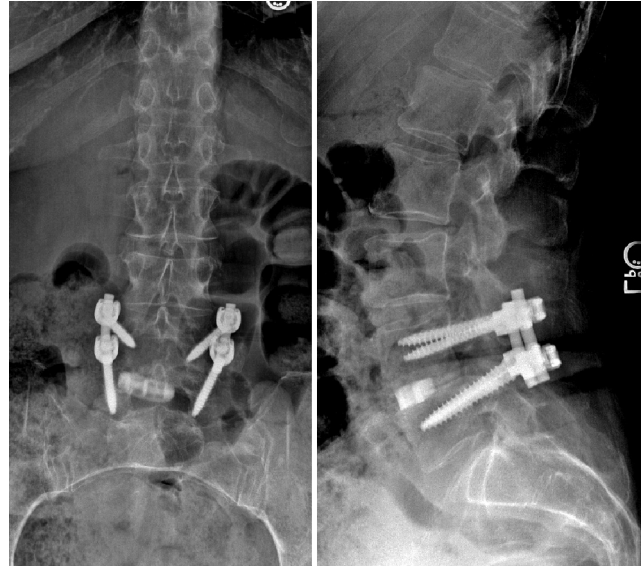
Upright postero-anterior (Left) and lateral (Right) radiographs of the lumbar spine performed 7 months after surgery demonstrate no instrumentation or interbody complications and suggest stable fusion.
